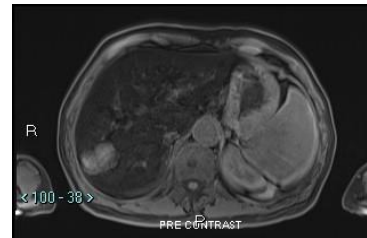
Non-contrast fat saturated T1 magnetic resonance imaging of the liver with diffuse low signal of hepatic parenchyma from iron deposition. The lesion in segment VII is minimally T1 high signal.
